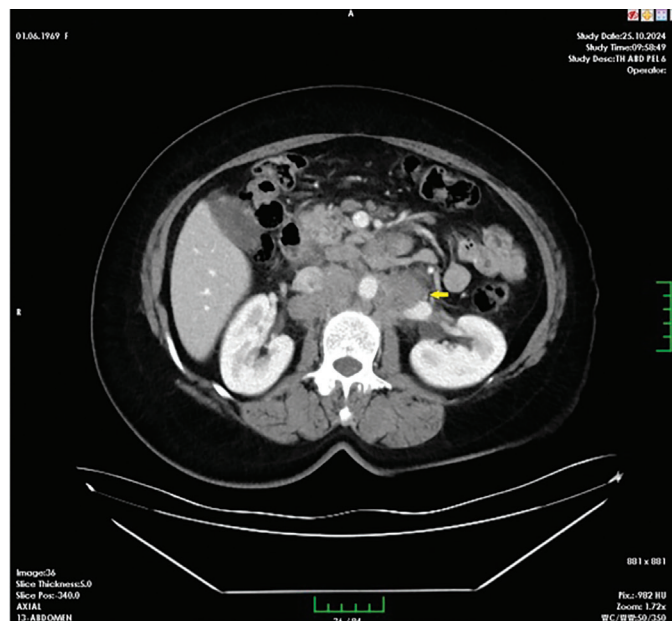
Baseline CT before initiation of mFOLFIRINOX (cycle 0)
